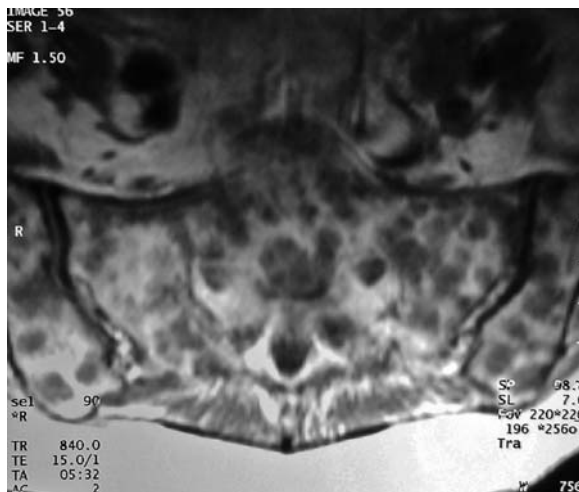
Axial non-enhanced T1-weighted axial image shows numerous focal lesions representing metastases in this 53-year-old woman
